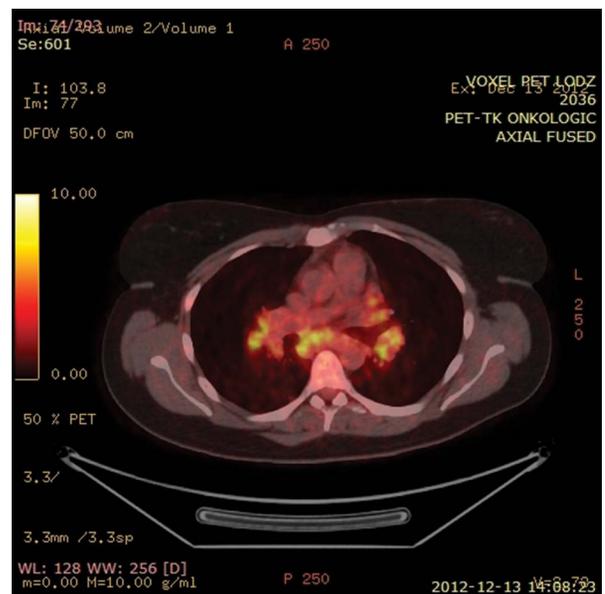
PET-CT axial view showing increased ^{18}F -FDG uptake in both hilar and subcarinal lymph nodes. The patient was suspected of lymphoma, after endobronchial ultrasound (EBUS) transbronchial needle biopsy sarcoidosis was confirmed
